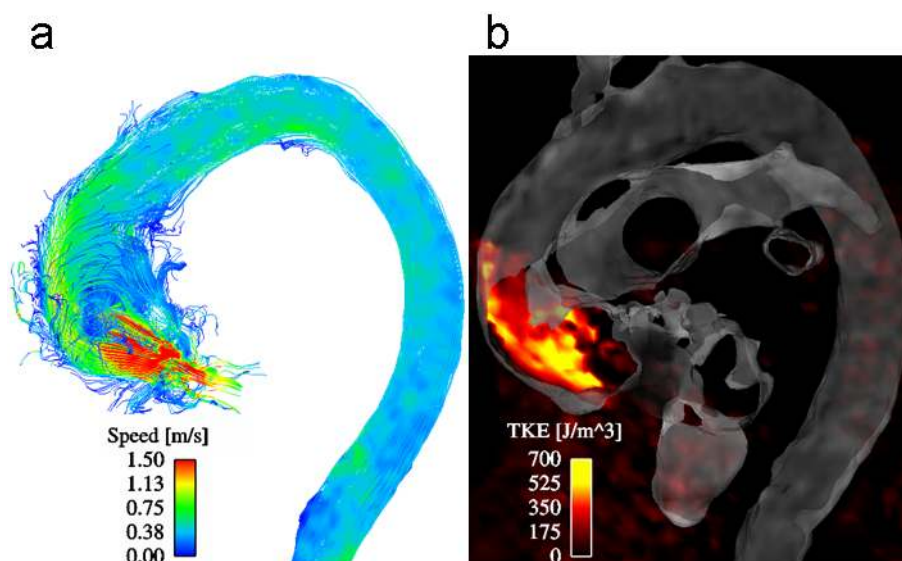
Aortic blood flow at peak systole in a patient with an aortic valve prosthesis visualized by 3D streamlines (a) and a TKE map showing the turbulence intensity in combination with a semi-transparent iso-surface rendering computed from the PC-MRI data (b).
